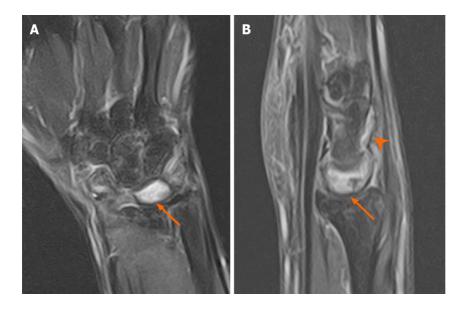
Two months postoperative magnetic resonance imaging showed residual bone edema of the lunate. A: Magnetic resonance imaging (MRI) in T2W coronal Fat saturation (FS) showed residual bone marrow edema in scaphoid, triquetrum and particularly, the lunate (arrow). This finding might be attributed to the post-traumatic or postoperative change; B: MRI in T2W sagittal FS showed lunate bone marrow edema and effusion in the intercarpal joints (arrowhead).
